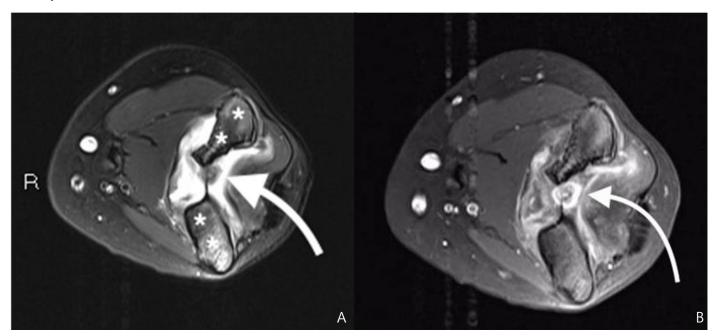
MRI left elbow axial images (A) T2 fat-suppressed shows the 8mm distal humeral osteoid osteoma nidus (arrow) and surrounding bone marrow oedema (*) with large elbow joint effusion. (B) T1 fat-suppressed with contrast show the enhancing nidus (arrow) and synovial enhancement.
